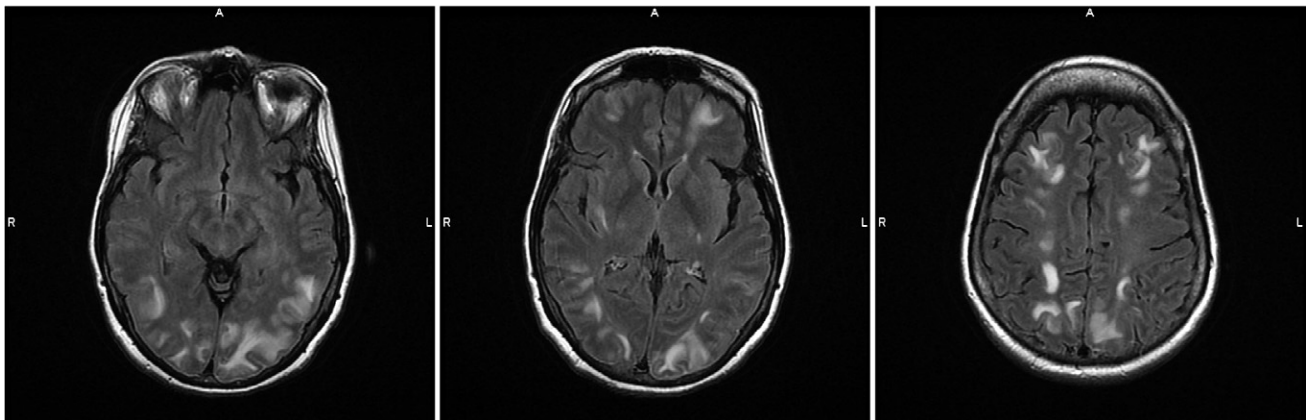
Initial MRI Brain Axial FLAIR With Extensive Subcortical White Matter Lesions Involving all Lobes Bilaterally, as well as the Right Cerebellum (Not Pictured). Note that all Lesions Spare the Gray Matter of the Cortex.
